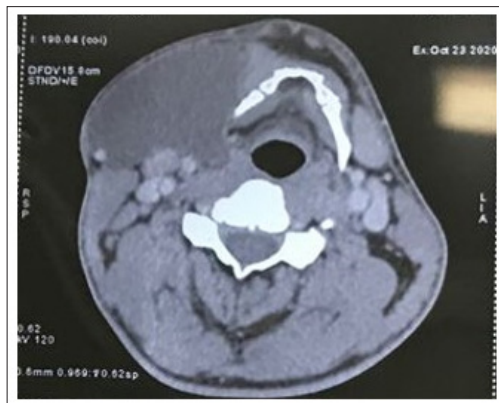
axial view of CT-scan showing second branchial cyst
